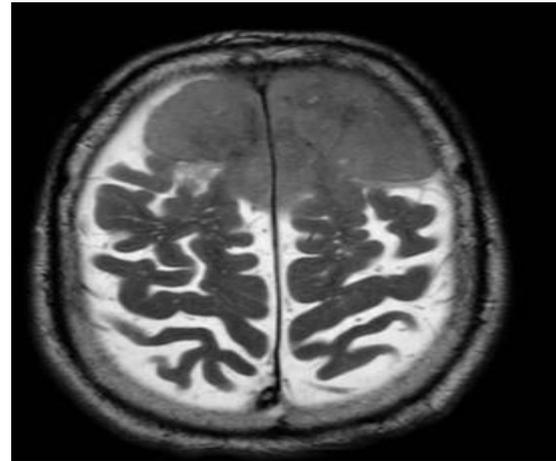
MRI with contrast demonstrate a very large bifrontal extraaxial mass which has a large dural base and enhances homogeneously.
